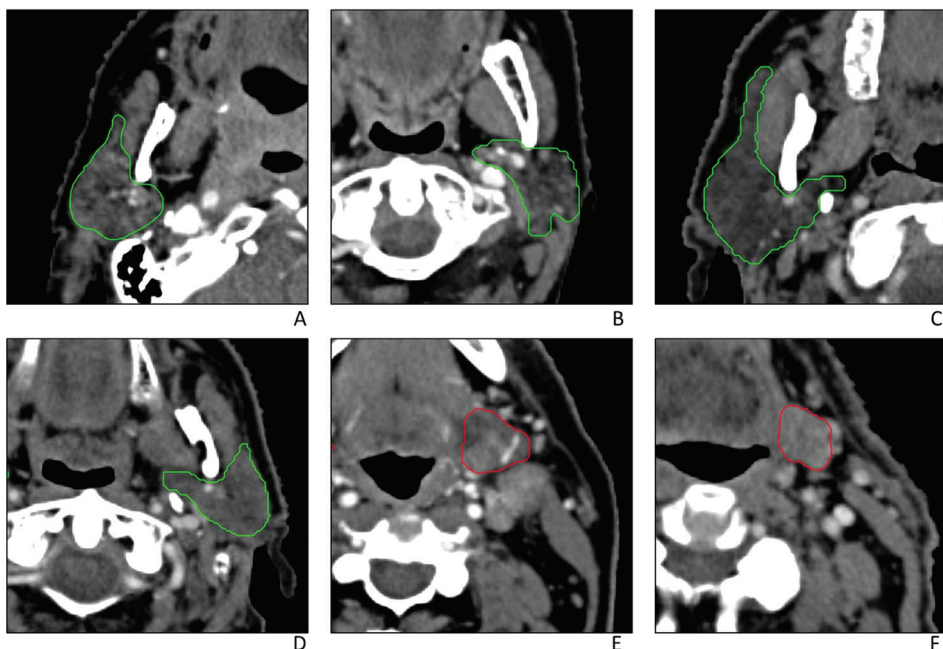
Examples of patients with high (A-B) and low (C-D) Short Run Emphasis values of the parotid gland. Examples of submandibular glands with high (E) and low (F) maximum CT intensity value.
